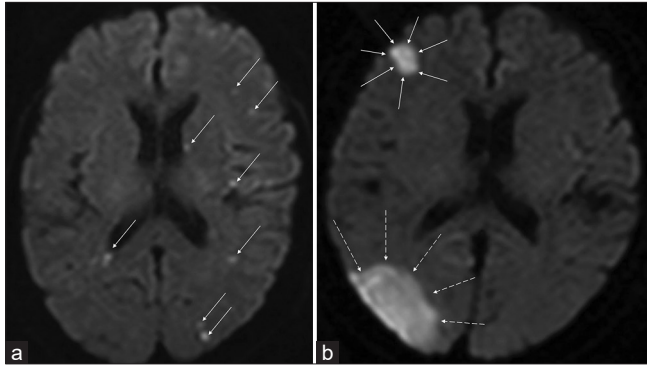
Method of calculating the diffusion-weighted imaging (DWI) score. Every high-intensity DWI spot (a: each indicated by an arrow) or area (b: surrounded by arrows or dotted arrows) is calculated as 1; every spot (a) is counted in each image slice, but a DWI area (b) exists over multiple slices; thus, the whole lesion over slices is counted as 1. The sum of these DWI findings is defined as the “DWI count.”
